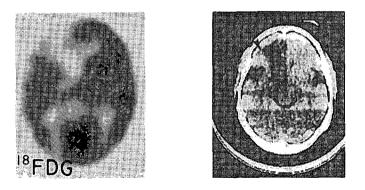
Scans made two months after sudden transaction of the left internal carotid artery by a knife wound. Although both the ¹⁸FDG and x-ray CT scans show the focal infarct in the left frontal lobe, only the ¹⁸FDG scan shows the diffuse hypometabolism throughout the entire left hemisphere, a permanent result of the left hemispheric ischemia [10].
